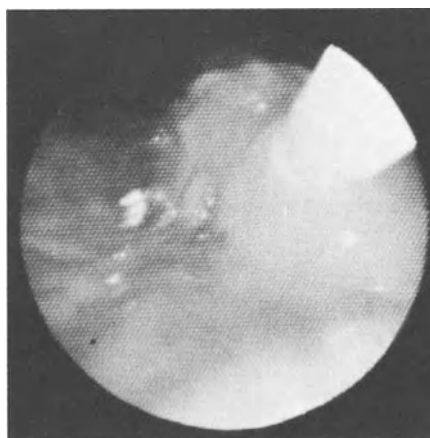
Closure of the bronchus stump by transthoracic application of fibrin sealant alone
